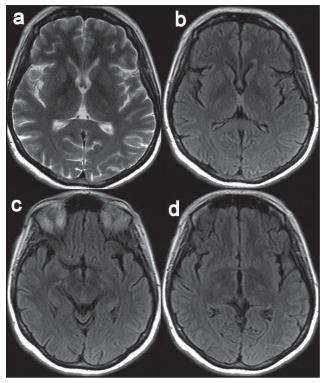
After 10 days of thiamine treatment, axial FLAIR and SE T2-dependent images showed improvement in pathologic signaling in both medial thalamic regions (a), mammillary bodies (b), periaqueductal gray substance (c), and wall of the third ventricle (d).
